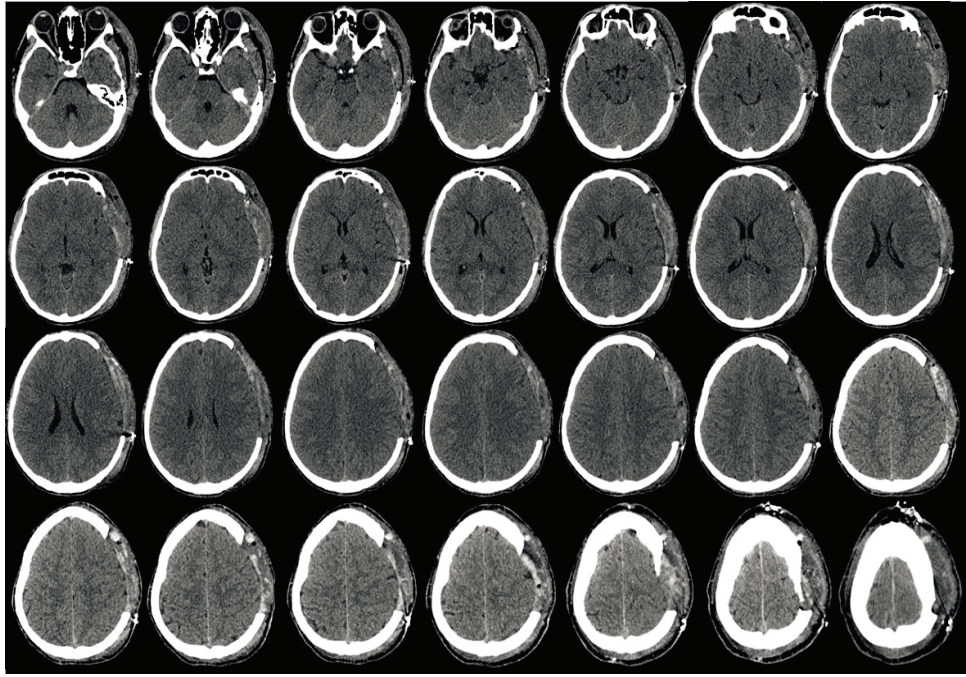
CT scan images of patient with right side parietal bone fracture
